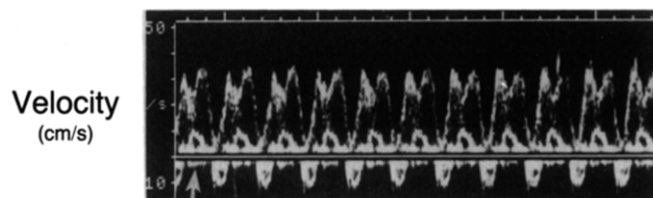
Doppler signals generated by fluid and tubing motion. The frequency of the motion of the tubing and the frequency of the peristaltic pump were varied. The frequencies of two motions were no longer integral multiples of each other and thus were desynchronized. The relative magnitude of the measured signals during the cycle varies even though the actual frequencies and velocities of motion and flow were constant. Arrow indicates a cycle in which the two motions are in phase, yielding the highest measured velocity.
